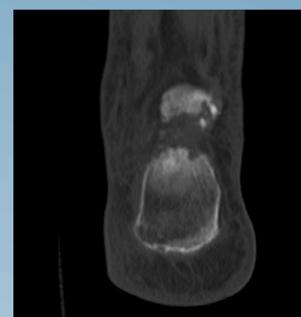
CT at admission
